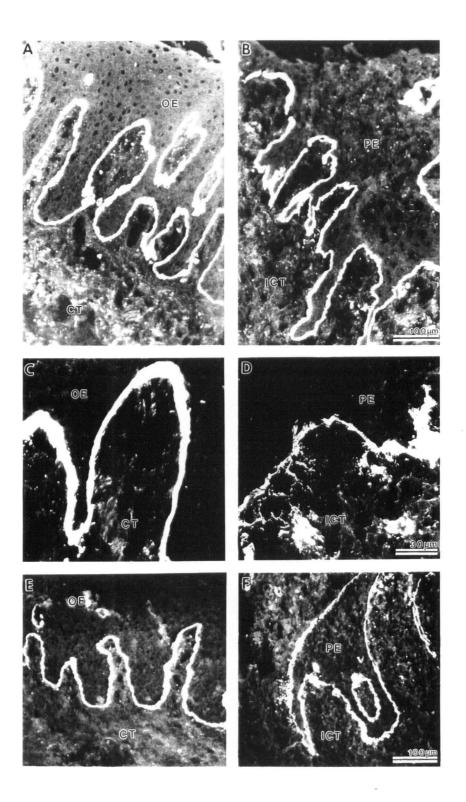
Immunolocalization of type VII collagen (A-D) and LM-5 (E, F) in healthy oral mucosa (A, C, E) and in chronically inflamed periodontal tissue (B, D, F). OE; oral epithelium; CT; connective tissue; PE; periodontal epithelium in chronic inflammation; ICT; inflamed connective tissue. Bar 100 μ m: A, B, E, F; bar 30 μ m: C, D.
